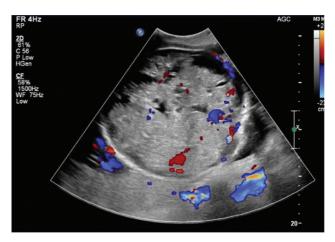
Ultrasound image with unamplified color Doppler signals over the intracranial mass ruling out vascular tumor.
